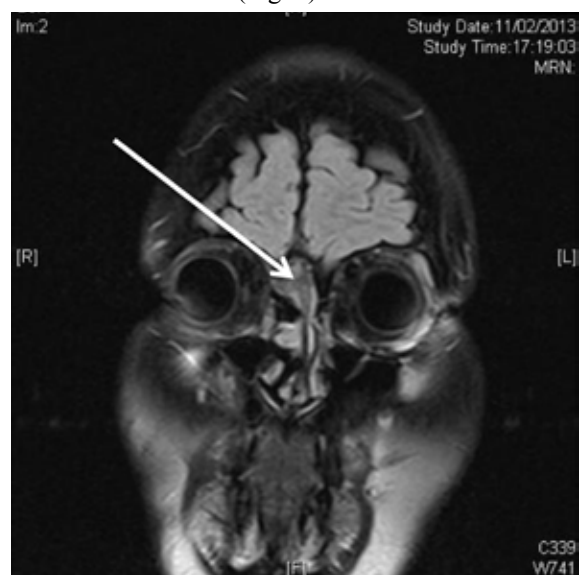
Craniofacial Contrast MRI which revealed an enhancing lesion involving the crista galli and cranial aspect of the nasal bone with an enhancing dural tail on the right extending between frontal lobes with no parenchymal involvement.
